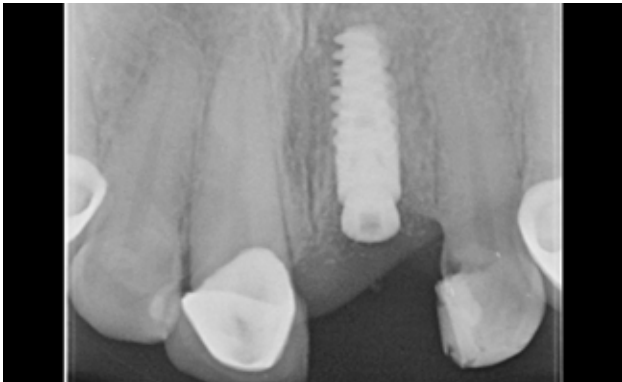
Radiographic verification of the implant position before inserting the provisional.
